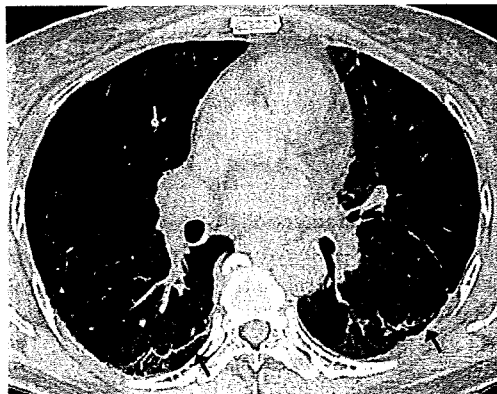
Nonspecific interstitial pneumonia (NSIP) associated with SSc in a 52-year-old woman. Transverse thin-section CT (2-mm collimation) at the level of the right superior pulmonary vein demonstrates areas of air-space consolidation (arrows) with a predominantly peripheral distribution.
